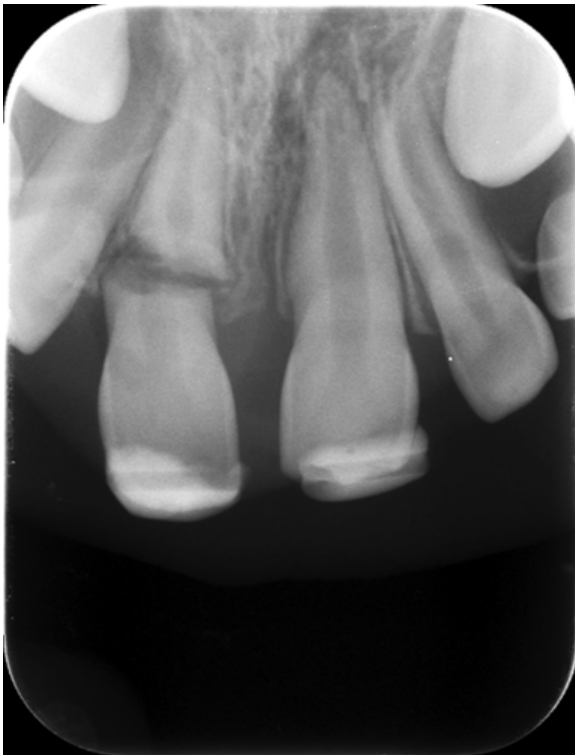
Radiograph Showing Extrusion of Coronal Fragment at 20 Months
